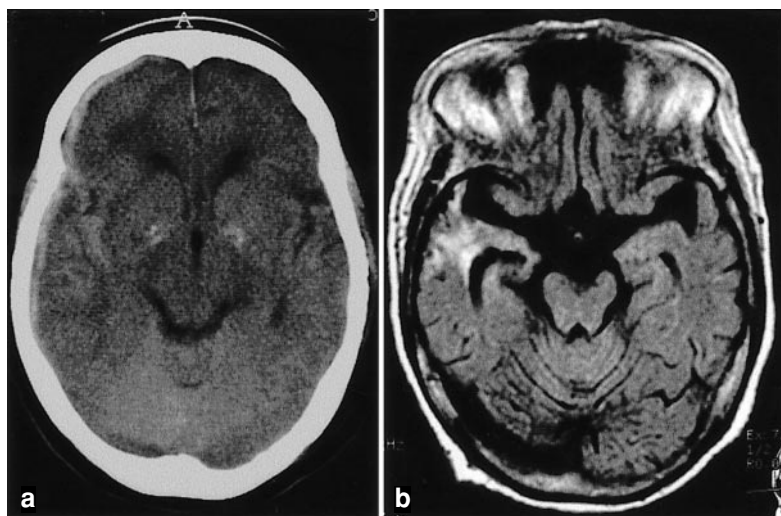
CT scan revealed a right subdural hematoma (a), and MR imaging on Day 4 showed a right temporal contusion (b)
